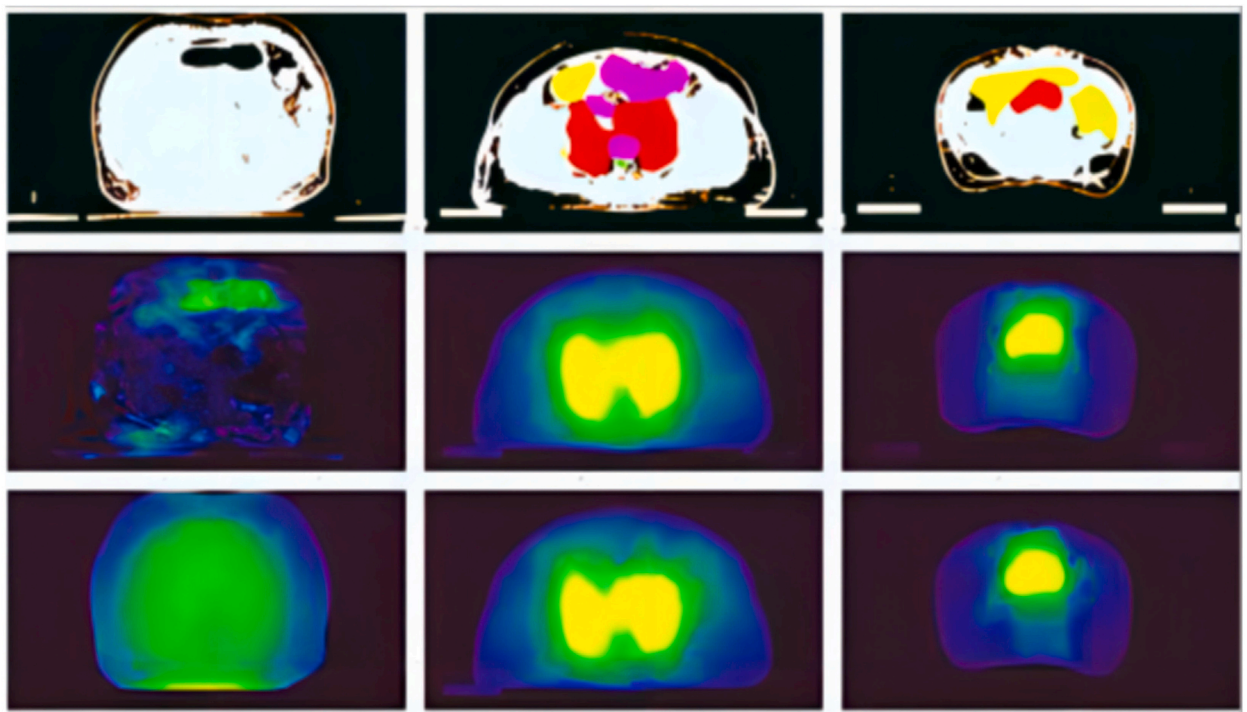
Comparison examples of predicted and true dose; the plot was obtained by random sampling; the first line: CT images; the second line: the true dose map; the third line: the predicted dose map.
